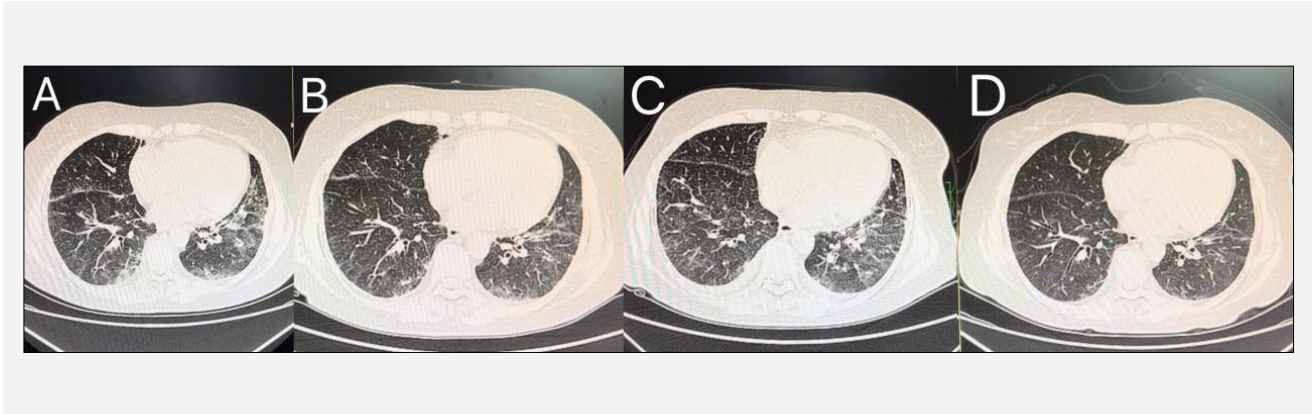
Chest CT Changes.
